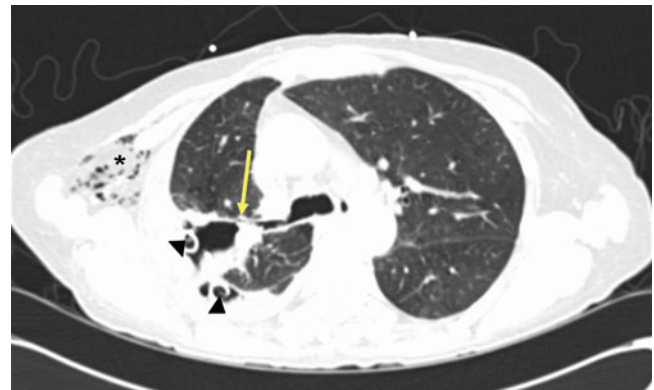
CT appearance of BPF (arrow) in right upper lobe. Note chest tubes (arrowhead) and subcutaneous emphysema (asterisk) in this postoperative patient
